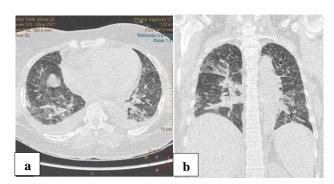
HRCT chest (a) axial and (b) coronal reveals multifocal consolidative opacities and nonsegmental areas of ground glass attenuations in both lung parenchyma with peripheral predominance and mild pleural effusion.
